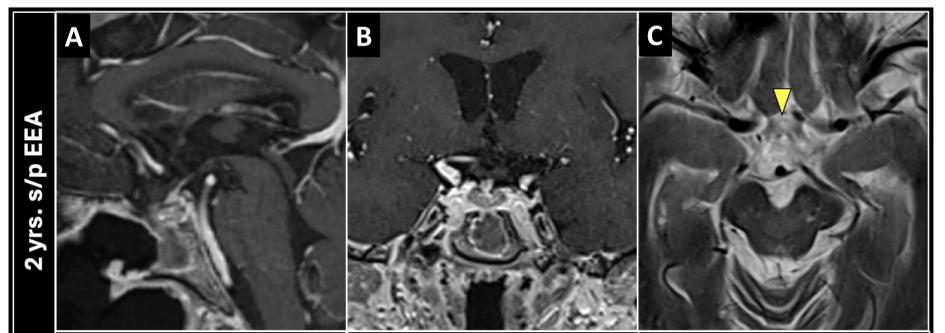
2-year postoperative sagittal (A) and coronal (B) T1 C+ MRI. Postoperative axial T2 (C) demonstrates decompression of the optic chiasm (yellow arrowhead).
